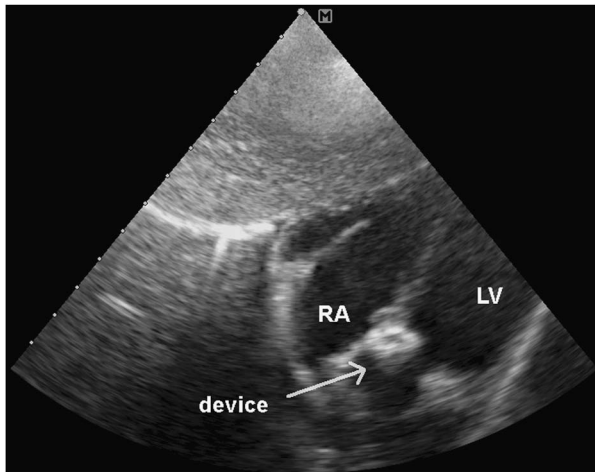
Echocardiography showing the device in position. RA = right atrium; LV = left ventricle.
